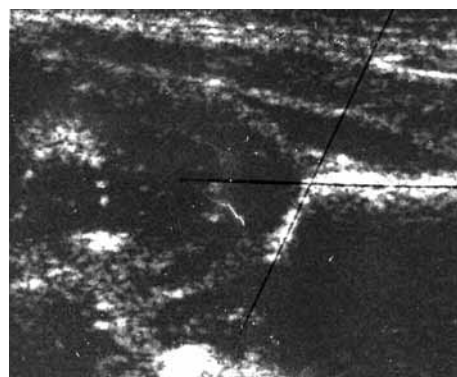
Case 1. Ultrasound scan of the left hip taken at one week of age showing no evidence of subluxation or dislocation on dynamic assessment and an alpha-angle of 67 degrees.
